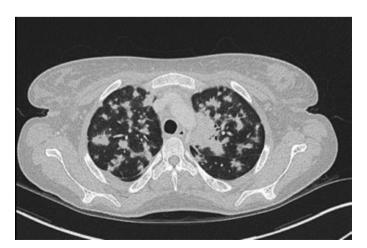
CT scan showing nodular infiltrates with peribronchovascular distribution due to Kaposi's sarcoma.
